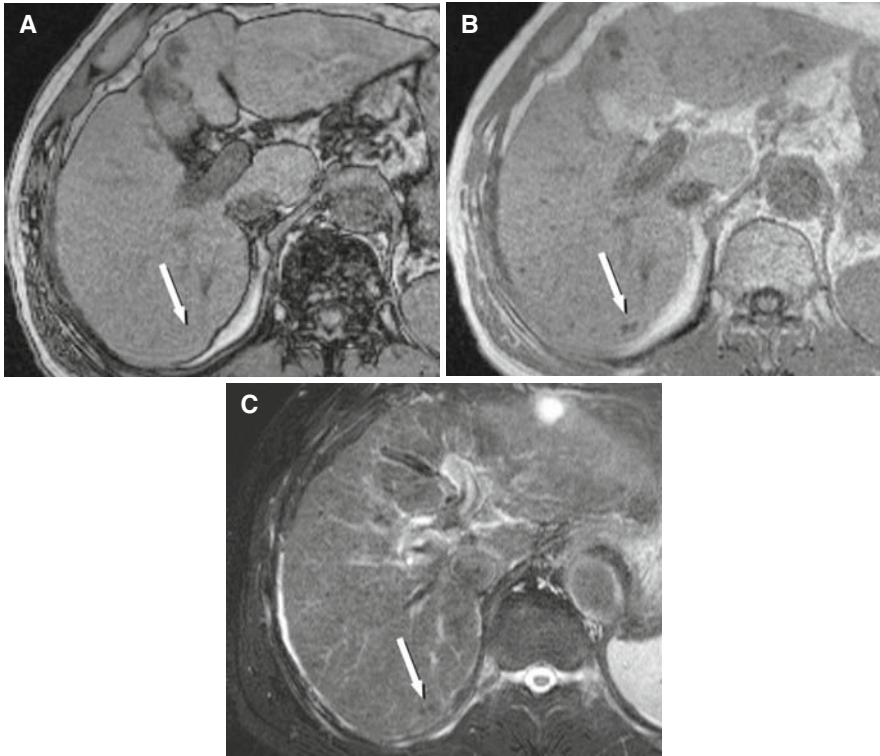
Regenerating nodules. (A) Out-of-phase T1-weighted gradient echo (TE = 2.2 ms) image shows faint low intensity representing siderotic nodules in segment VI. (B) In-phase T1-weighted image (4.2 ms) demonstrates darker (hypointense) and blooming subcentimeter lesions in corresponding area. (C) T2-weighted image shows the same lesion is also hypointense to liver.
